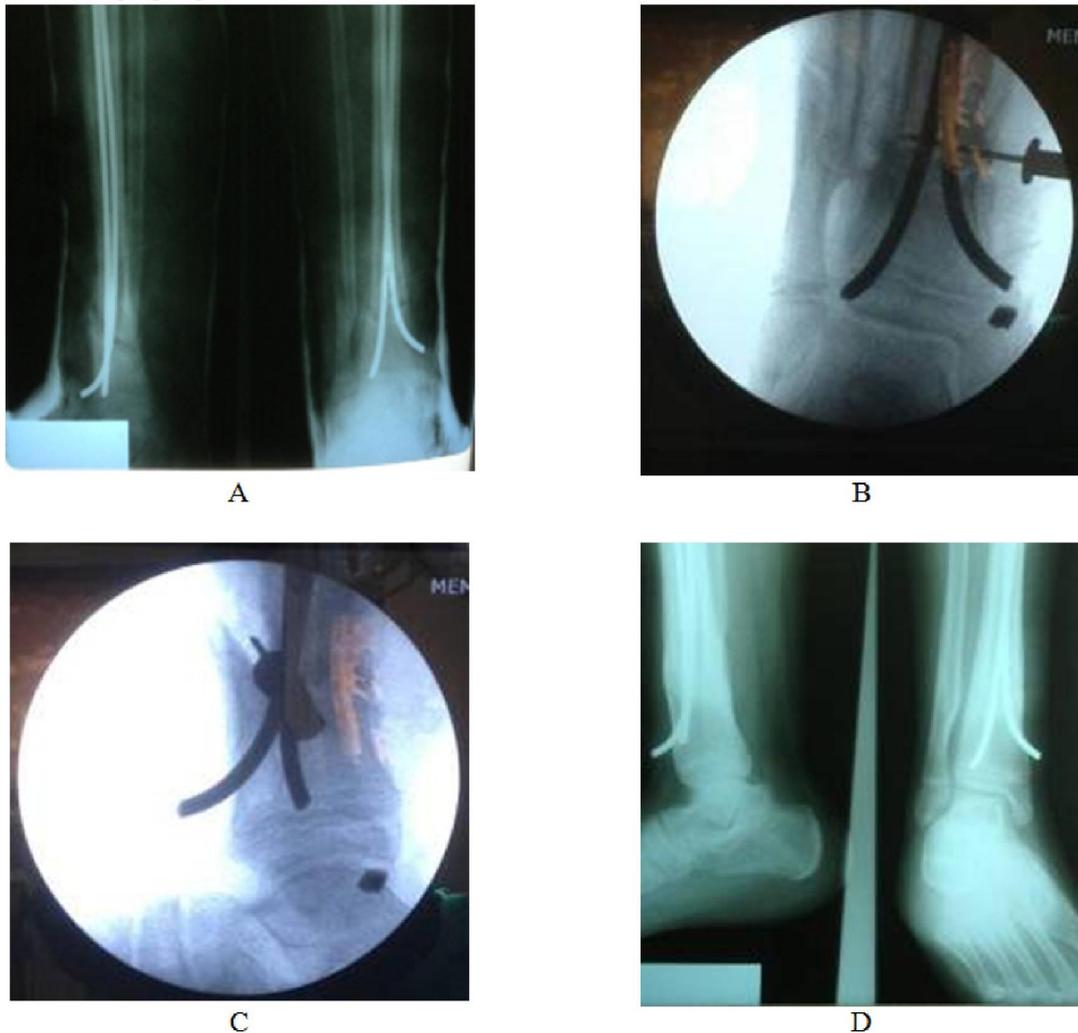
A 15-year-old man, 5.9 months after road traffic accident and a open distal tibia–fibula fracture treated intramedullary flexiabile nails fixation. At presentation in our facility, the Pre-operative anteroposterior radiograph (A) and Immediate intra-operative radiograph by C-arm (B, C) showed a nonunion at the fracture site with 0% cross-sectional healing. At 6 months after the percutaneous autologous bone marrow injection, the patient's radiograph (D) showed solid bony union. At final follow-up 12 months after marrow injection, the patient reported large improvements in pain (13/50 according to Calori et al (1). nonunion scoring system).
